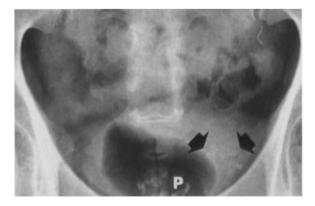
Calcification in bladder neoplasm. Stippled calcification is seen on the plain film (arrows); calcification is also present in the prostate gland (P)
